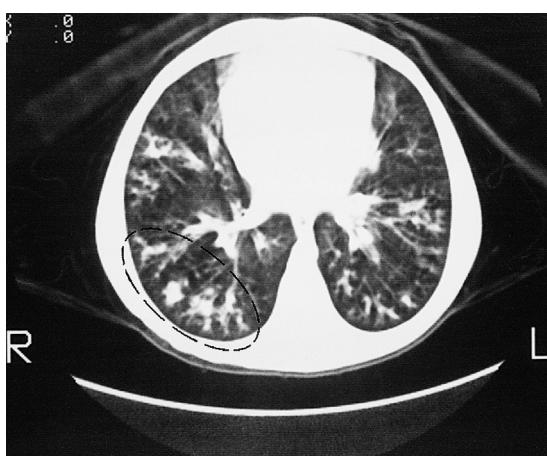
Bronchiectatic changes are seen peripherally on this CT scan of the lungs from a 9-year-old patient with cystic fibrosis. (From American College of Radiology, Reston, Virginia.)
